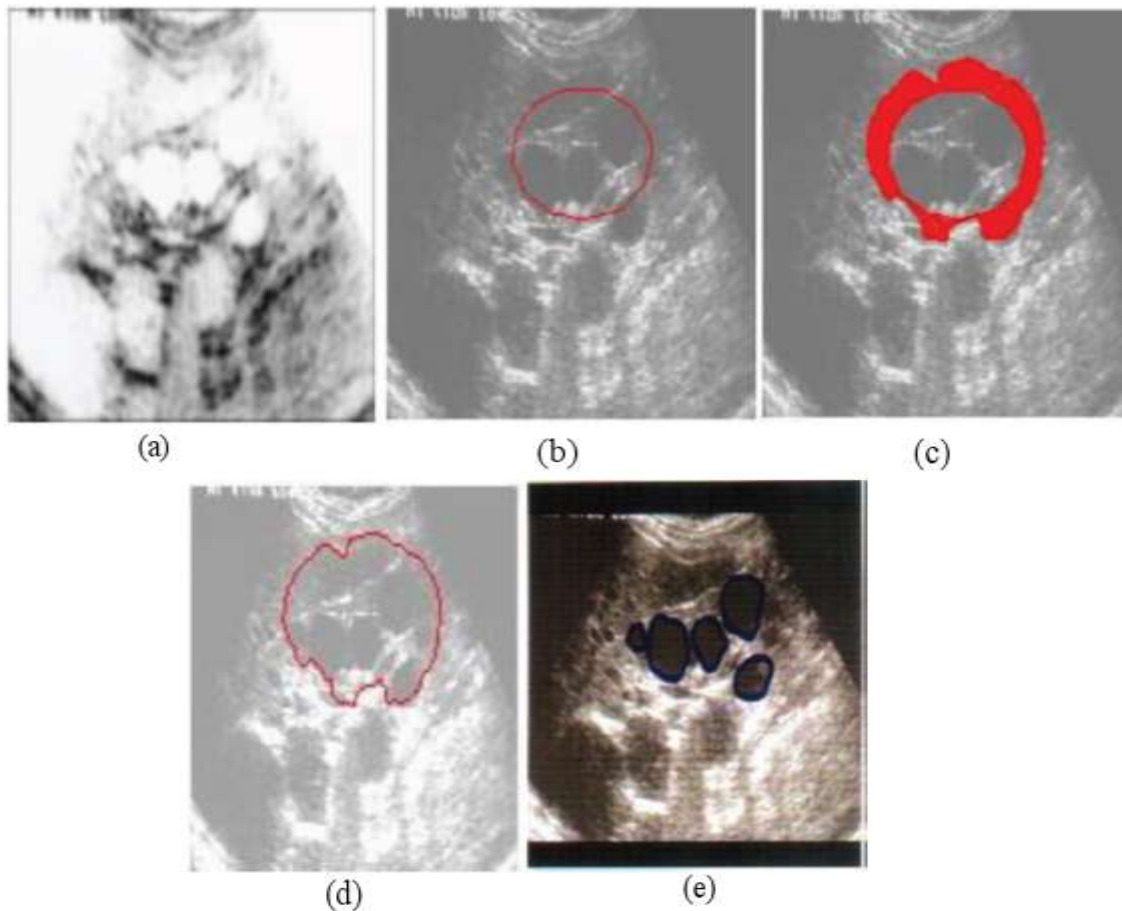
Segmentation of polycystic kidney using GVF model: (a) Denoised polycystic ultrasound image of kidney (b) Predefined initial contour (c) Deformed intermediate image (d) Segmented image (e) Manually annotated image by medical expert
